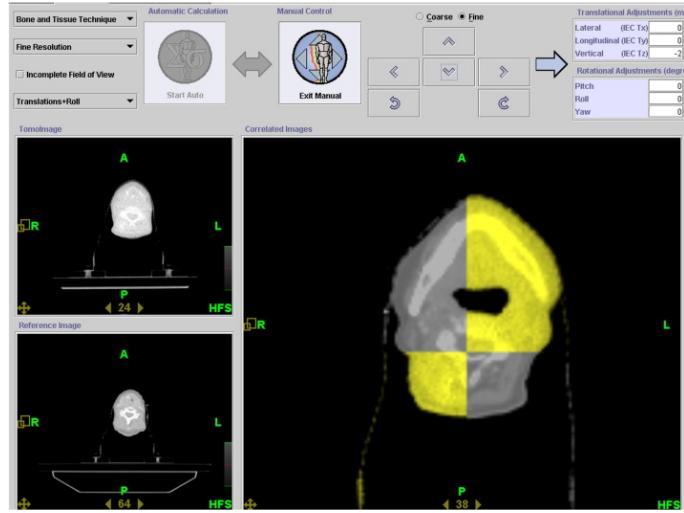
The original planning CT scan is “co-registered” with the current CT scan, to achieve alignment of internal structures. The direction and shape of the radiation beam is based off of the planning CT, so aligning with the planning CT ensures the beam will be directed at the appropriate target tissues. The two yellow quadrants represent the current day’s CT scan overlayed with the planning CT in the gray quadrants [IR10].
